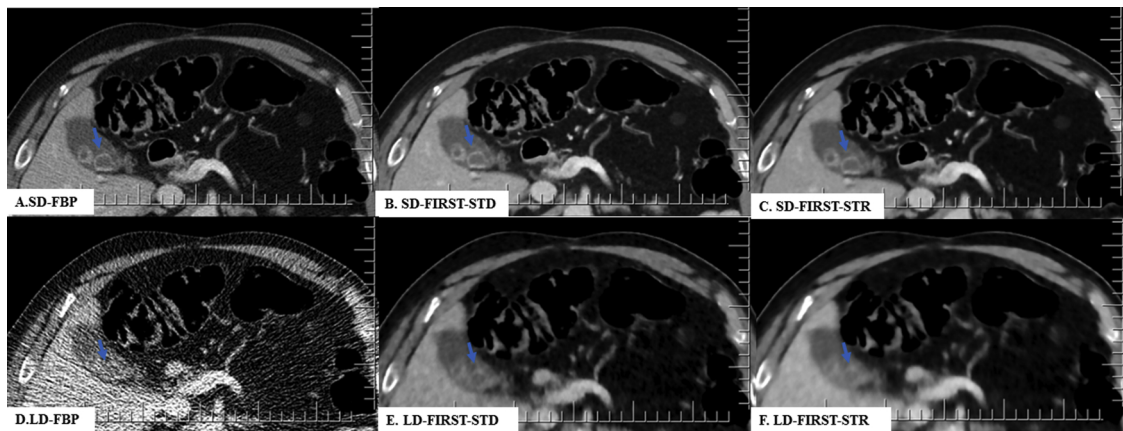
A 69-year-old man (BMI 31 kg/m²) underwent contrast-enhanced CT of the abdomen at SDCT (CTDIvol 16 mGy) and LDCT (1.7 mGy). All SDCT and LDCT images demonstrated cholelithiasis (arrow). LD-FIRST-STD image had lower noise and better diagnostic performance than the unacceptable LD-FBP image.
